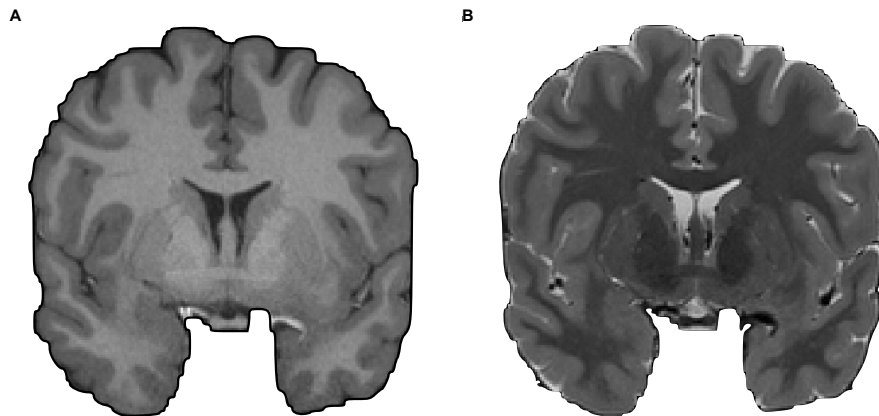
Two images of the same individual is displayed with different contrasts, acquired by altering the parameters of the MRI sequence: (A) T1-weighted (B) T2-weighted.
